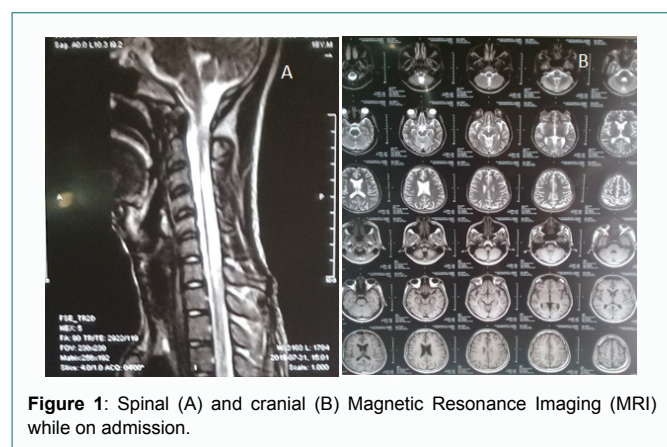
Spinal (A) and cranial (B) Magnetic Resonance Imaging (MRI) while on admission.
